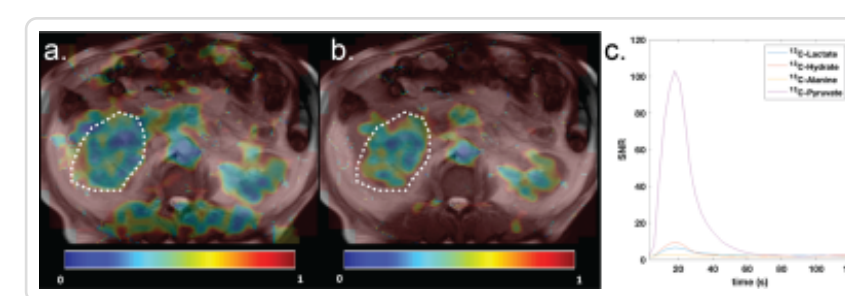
Example hyperpolarised MRI images overlaid on an axial T2W image from the patient with a clear cell RCC. (a) lactate:pyruvate AUC ratio map; (b) alanine:pyruvate AUC ratio map; (c) time course of the different metabolites detected from the tumour ROI.
